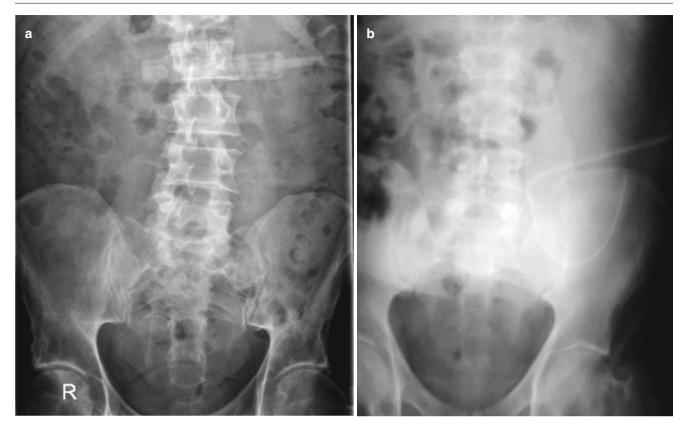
Plain abdominal X-rays demonstrating the PD catheter located in the pelvis (a) demonstrating a PD catheter where the tip has migrated out of the pelvis (b)
